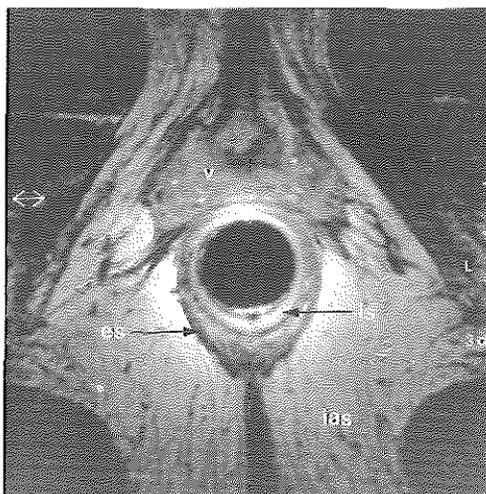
Axial endoanal proton density gradient-echo MRI (30/13) showing a normal sphincter complex: external sphincter (ES), internal sphincter (IS), ischioanal space (IAS), vagina (V).
